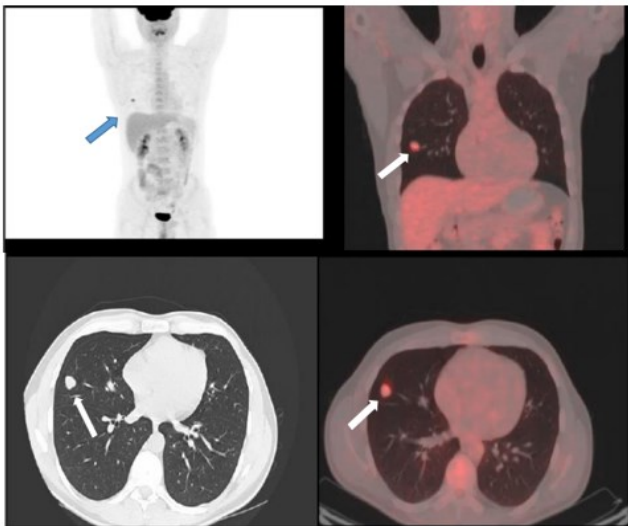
y.o male, with incidental finding on chest CT, RML SPN, with moderately increased metabolic activity, suspicious for malignancy; MIP, fused coronal, axial CT, axial fused images; morphology revealed atypic carcinoid
